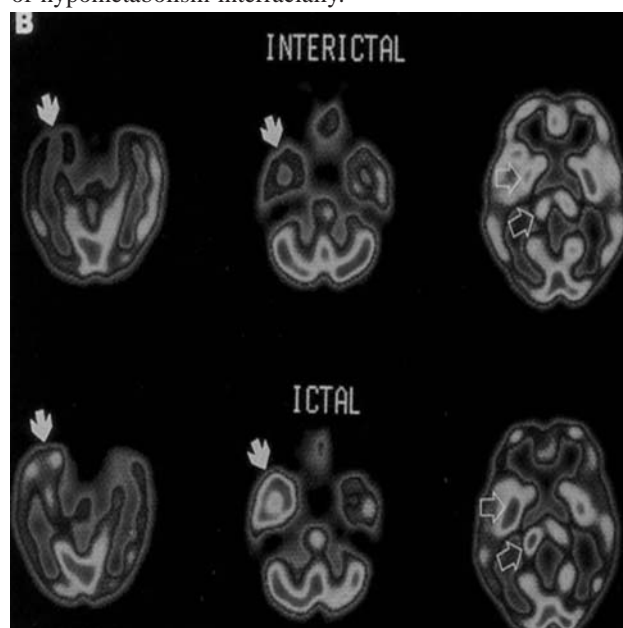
Coronal view of ictal brain SPECT in a patient with complex partial seizures showing hyperperfusion in right temporal lobe..
